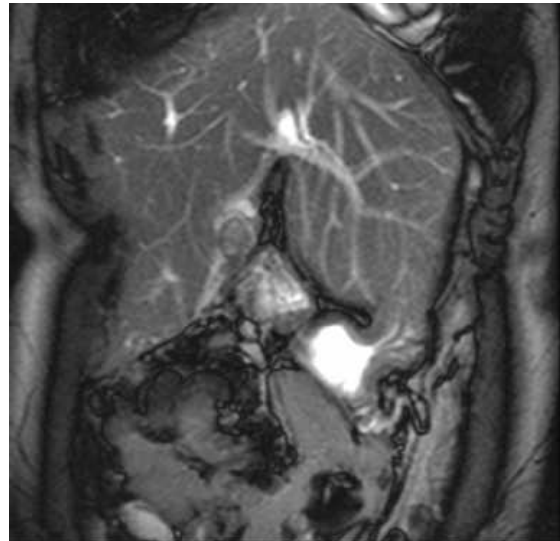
Postoperative MRI showing overall reduction in HCH size. Top = coronal view; bottom = transverse view.
